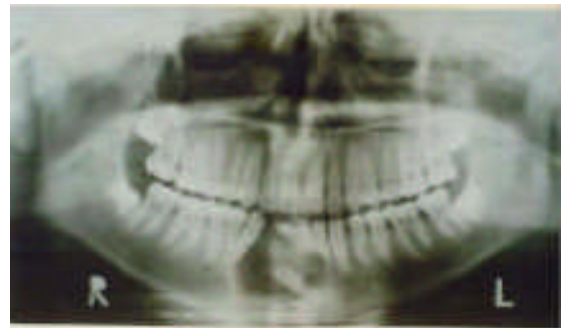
Orthopantomograph showing unilocular radiolucency with impacted mandibular lateral incisor.
